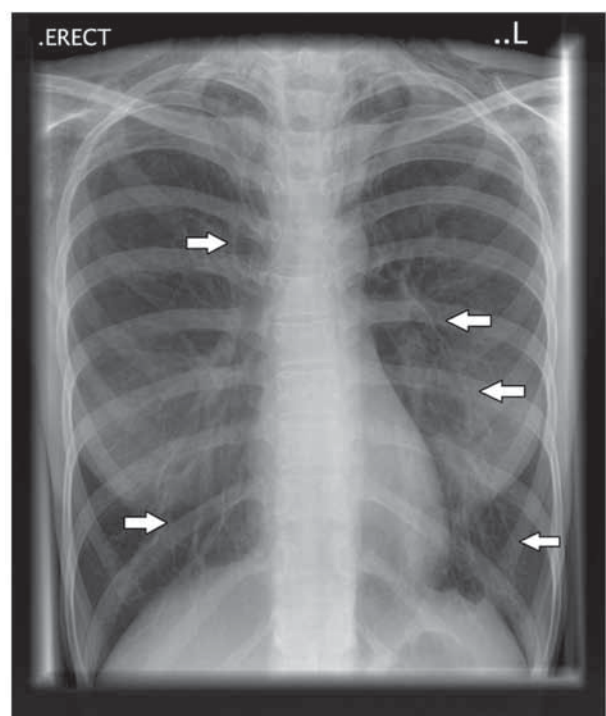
Pneumomediastinum seen on chest X-ray on the day of admission (white arrows).
